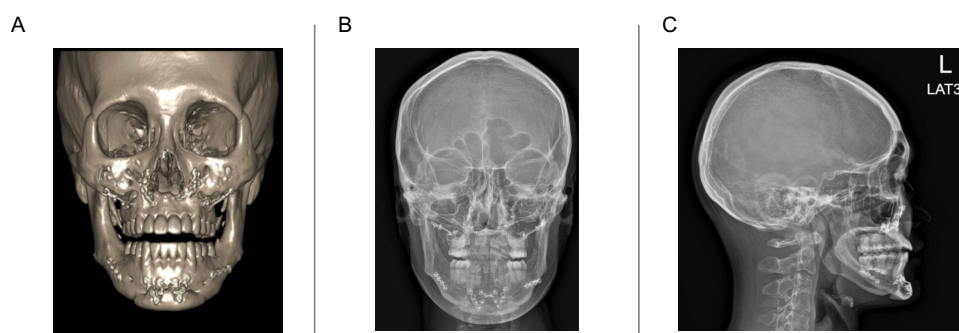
CT and X-ray films to locate implants. (A) CT scan, (B and C) X-ray films.
